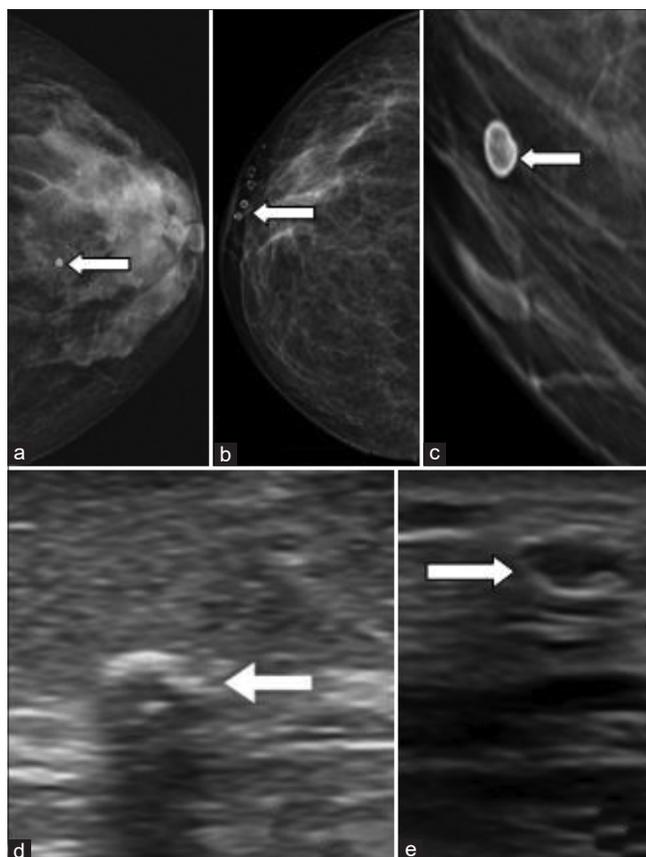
Different patients who came for routine annual checkup. (a and b) X-ray mammogram CC view and (c) zoomed-in view showing oil cysts with rim calcification (arrow). (d and e) Ultrasound images showing oil cyst with peripheral calcification (arrow)
